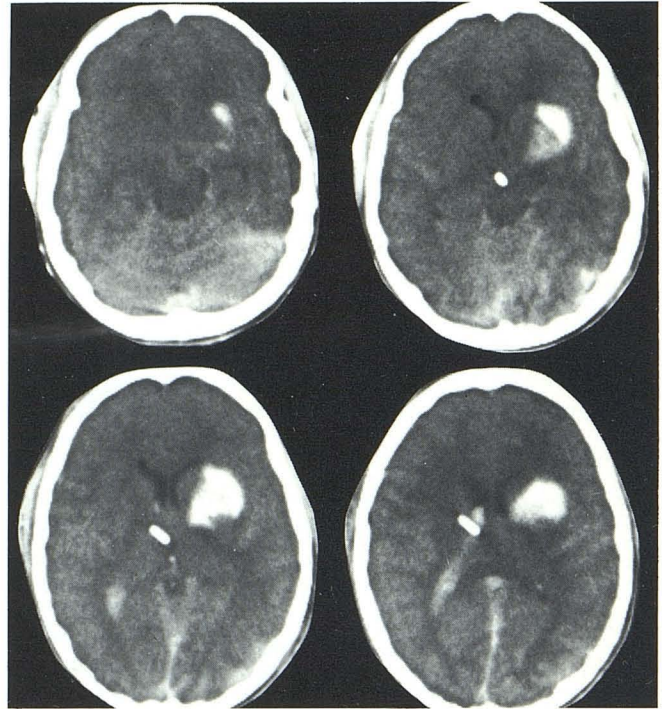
Left intracerebral hematoma and intraventricular hemorrhage on four successive CT slices.
